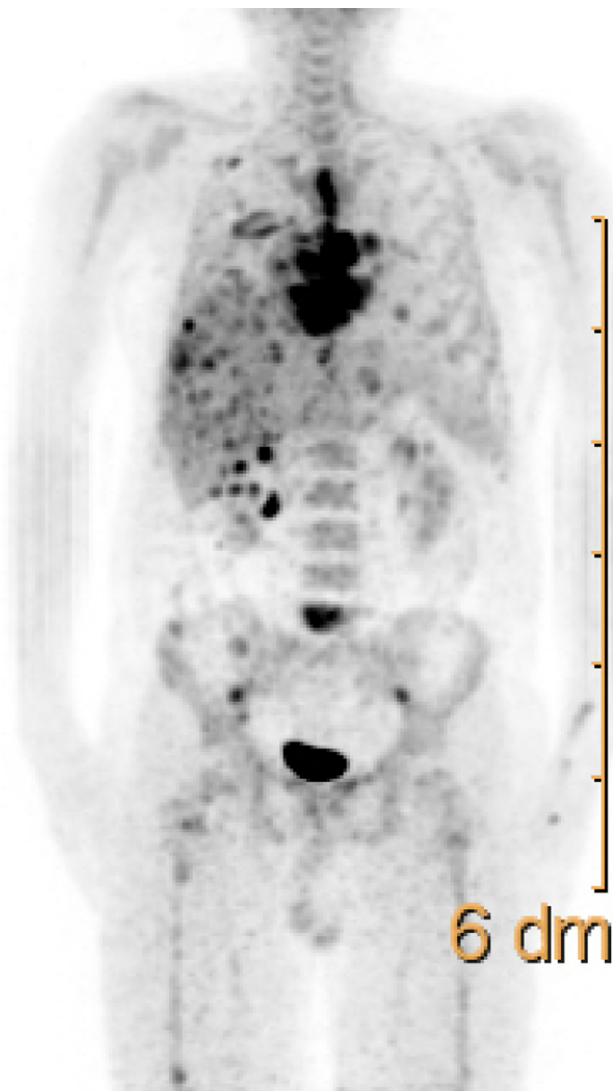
Maximum intensity projection image ¹⁸F-FDG PET-CT shows multiple distant metastasis in the lung, liver and bones. Abbreviations: CT, computed tomography; FDG, fluorodeoxyglucose; PET, positron emission tomography; dm, mean decimeter.
